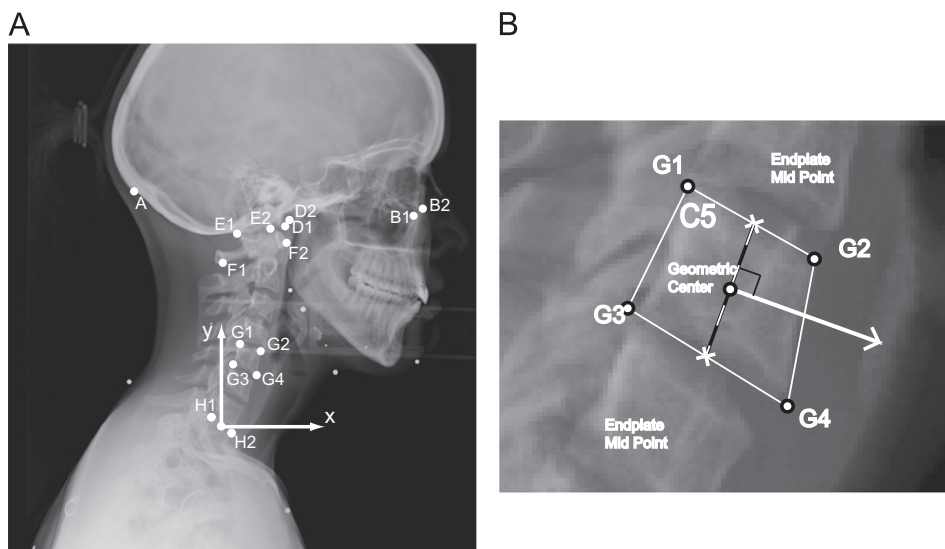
Identified landmarks and the coordinate systems defined in each radiograph. A. Landmarks include the external occipital protuberance (A), left and right inferior orbital socket (B1, B2), left and right tragus (D1, D2), opisthion (E1) and basion (E2), posterior and anterior tubercles of the C1 vertebrae (F1, F2), vertebral corners (G1–G4), and the corners of the T1 superior endplate (H1, H2). The origin of the T1 coordinate system was defined as the midpoint between H1 and H2, with the x -axis horizontal and the y -axis vertical. B. Vertebral coordinate system and orientation definition for the C5 vertebra, as an example.
